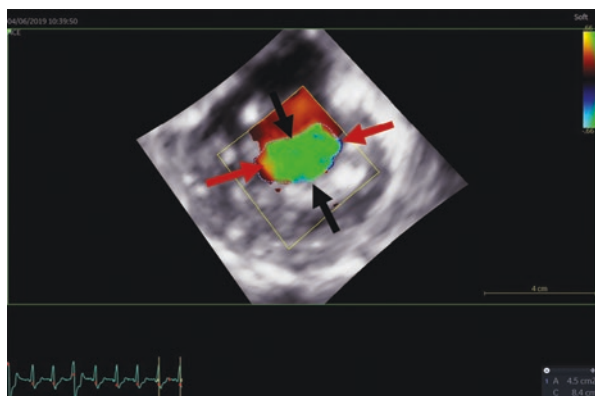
Vena contracta area (3D-guided 2D cross-section at the level of the vena contracta) in patient with large difference in linear dimensions in between two-dimensional echocardiography planes (small antero-posterior diameter in between the black arrows and large commissural diameter in between the red arrows)
